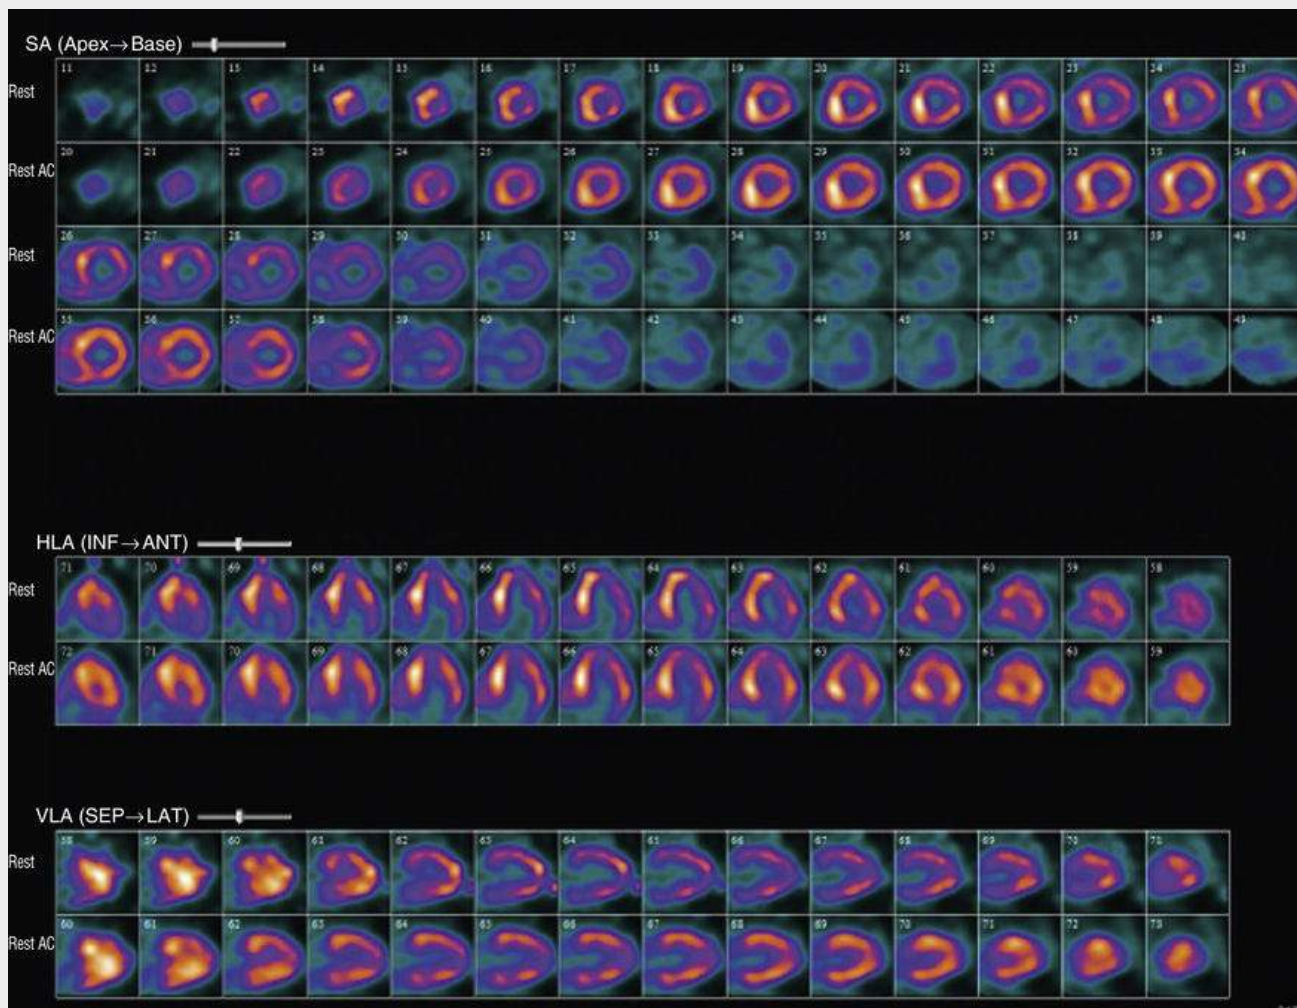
Technetium pyrophosphate scan in an 81-year-old patient with wild-type amyloidosis (ATTRwt.). Paired sets of images with nonattenuation-corrected images are labeled “rest,” and corresponding CT-based attenuation-corrected images are labeled “rest AC.” The patient had heart failure and marked wall thickening on his echocardiogram; he did not have any evidence of a plasma cell dyscrasia. The heart avidly took up the isotope (a normal heart exhibits no uptake). This is virtually pathognomonic of TTR amyloidosis. In this case, it was later confirmed by biopsy. Genetic testing for a *TTR* mutation was negative. AC, attenuation corrected; HLA, horizontal long axis; SA, short axis; VLA, vertical long axis. (Courtesy Dr. Sharmila Dorbala, Brigham and Women's Hospital, Boston.)
